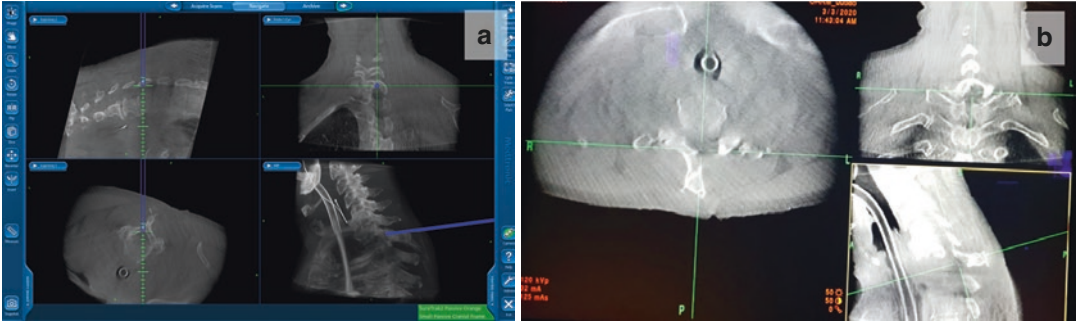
Navigation display. (a) A real-time navigation showing proper localization of the soft tissue dilator. (b) An intraoperative computed tomography scan after operation which confirms the location and amount of bony decompression
